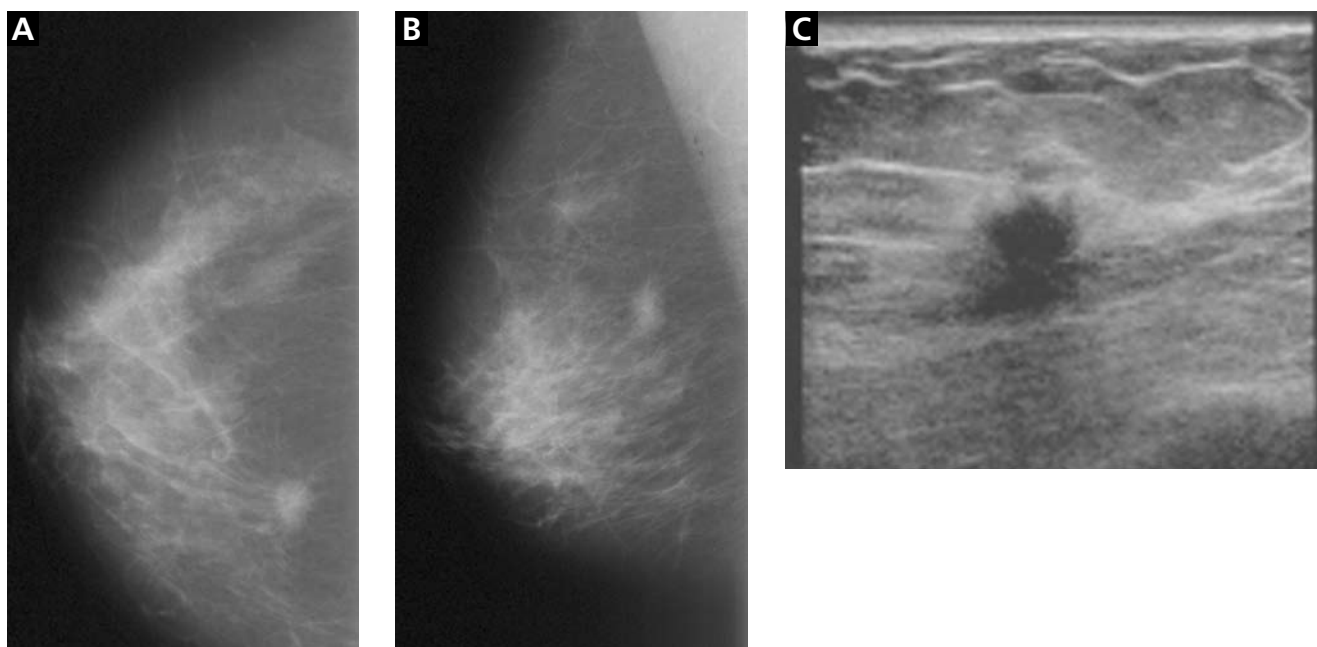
Infiltrating ductal carcinoma. Craniocaudal (A) and mediolateral oblique (B) mammographic views of the right breast show an irregular, mildly spiculated, high-density lesion in the posterior, medial breast. Ultrasonography (C) shows an irregularly shaped hypoechoic mass which is taller than wide (a profile tending to indicate malignancy) and has mild posterior acoustic shadowing.
